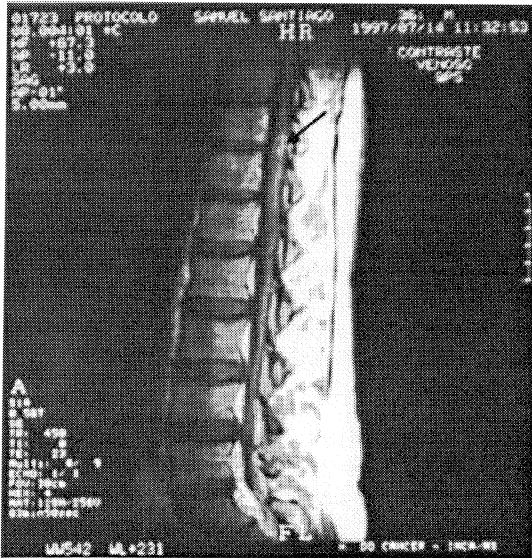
MRI showing a T₁₂ spinal cord oval lesion.
